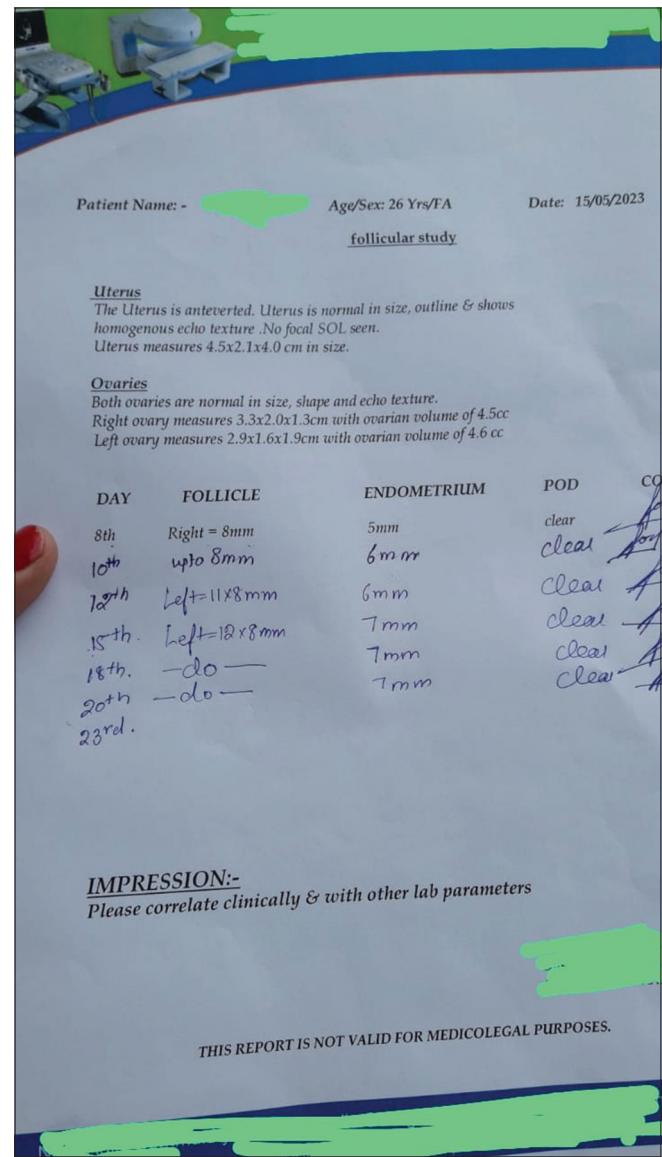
Sonography report before treatment
